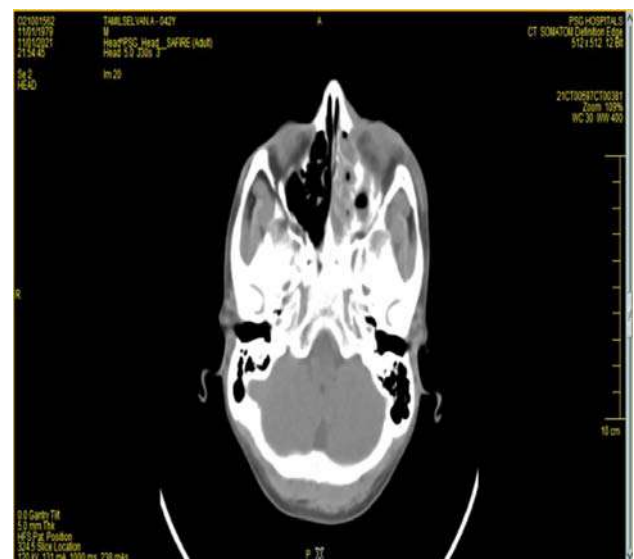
CT scan of paranasal sinus of one of the patients
